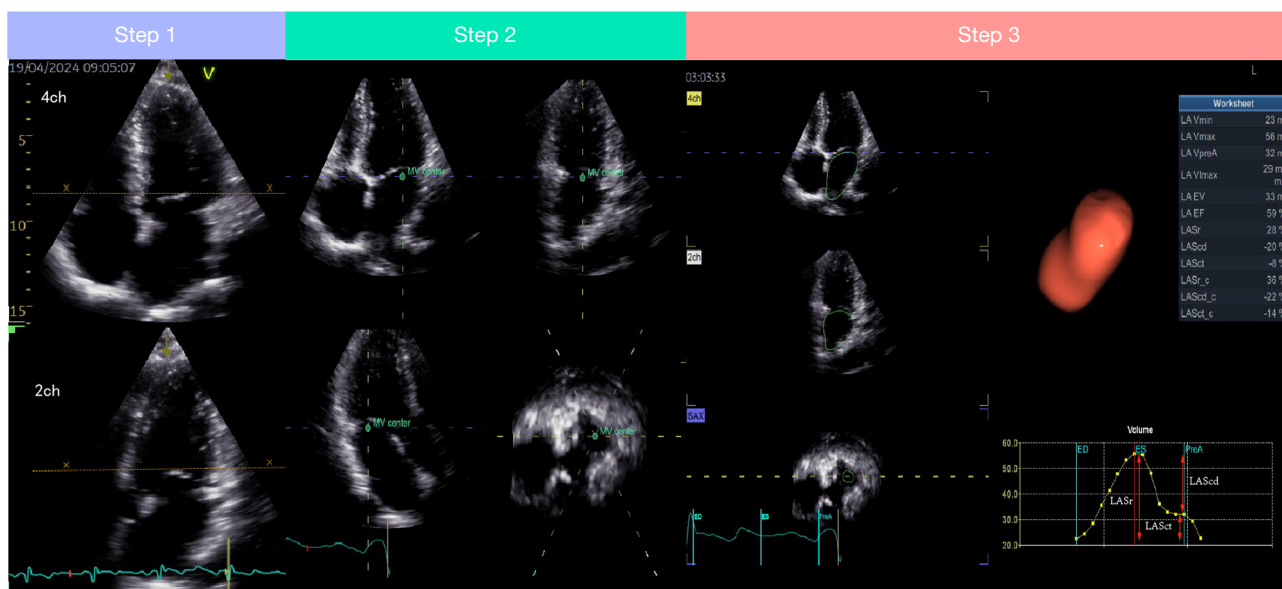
Specific steps for measuring left atrial strain using the real-time three-dimensional automated left atrial quantitative technique. Step 1, the three-dimensional volumetric probe is used to acquire an apical four-chamber view image of the focused left atrium, allowing for a clear demonstration of the motion of the left atrial walls; Step 2, the imaging axis is manually moved to the left atrial chamber's center in the apical four-chamber view, apical two-chamber view, and apical three-chamber view; Step 3, the left atrial myocardium is quantitatively analyzed by the software through automatic myocardial tracing. This results in the creation of a three-dimensional left atrial pattern map, a left atrial strain curve, left atrial volumetric parameters, and three-phase longitudinal and circumferential left atrial strain values. 4CH, apical four-chamber view; 2CH, apical two-chamber view; LASr, left atrial reservoir strain; LAScd, left atrial conduit strain; LASct, left atrial contractile strain.
